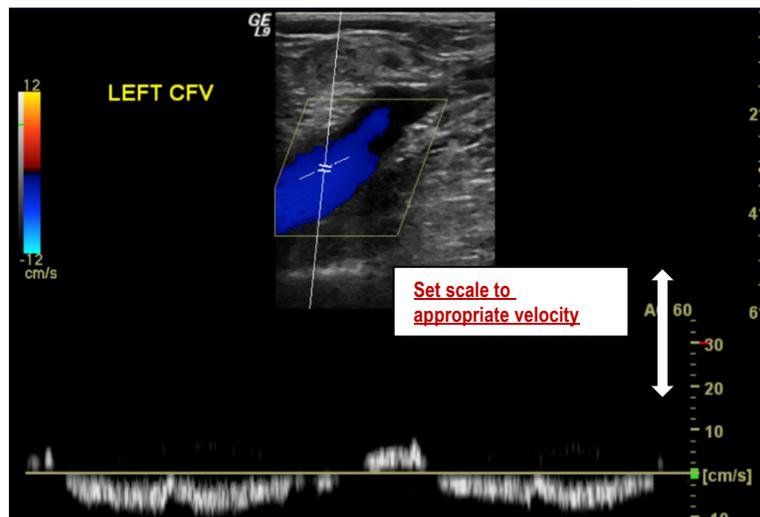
Phasicity documented with Spectral Doppler
